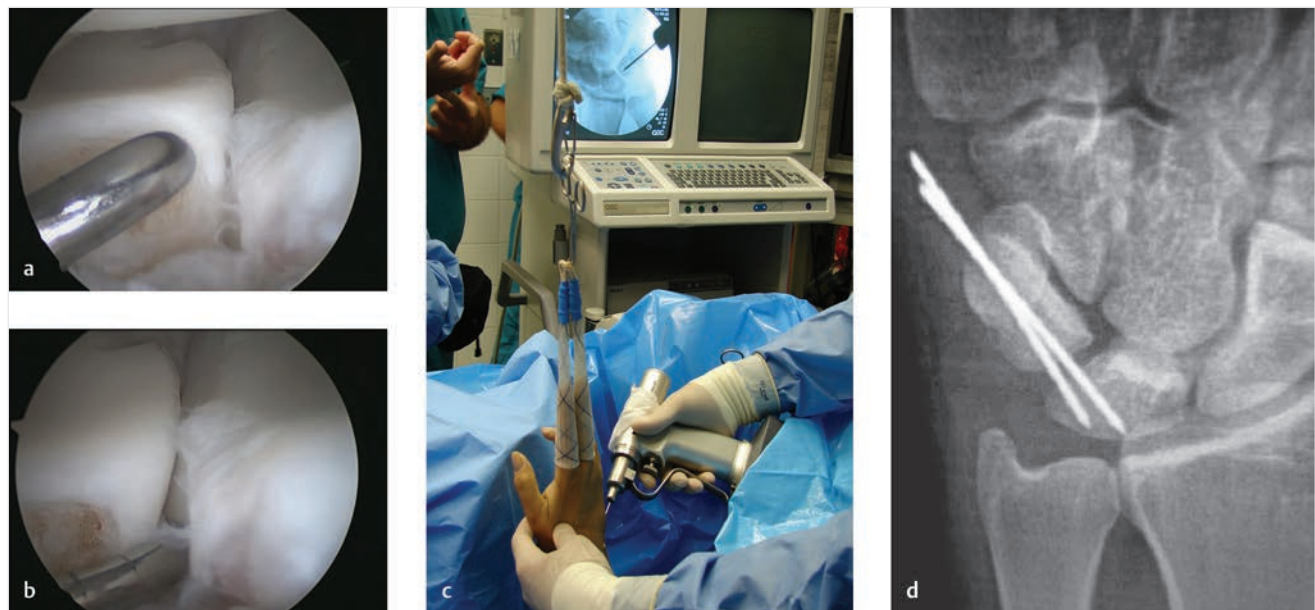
(a) Lunotriquetral (LT) instability noted via midcarpal arthroscopy. (b) A Geissler grade 3 LT tear demonstrated with hook probe. (c) Pinning of LT interval (external view). (d) Radiograph of LT pin placement.
